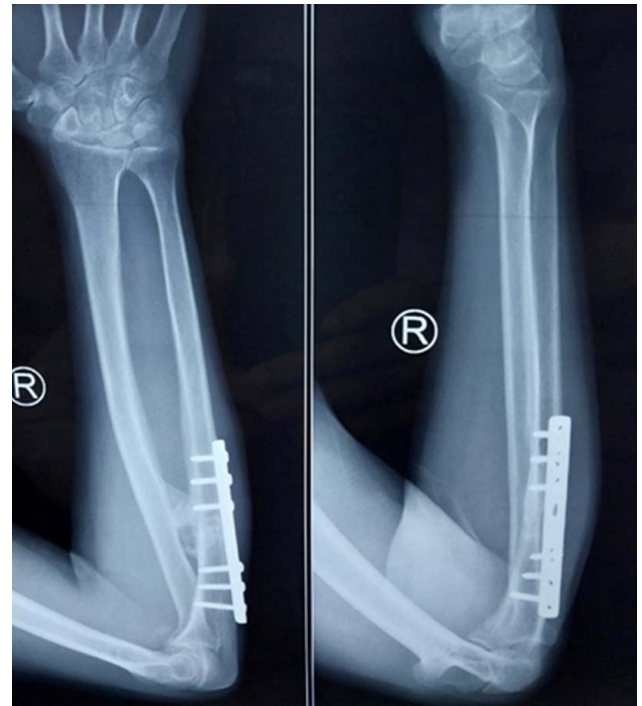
Plain X-ray of right forearm showing united proximal ulna fracture with synostosis and implant in situ.
